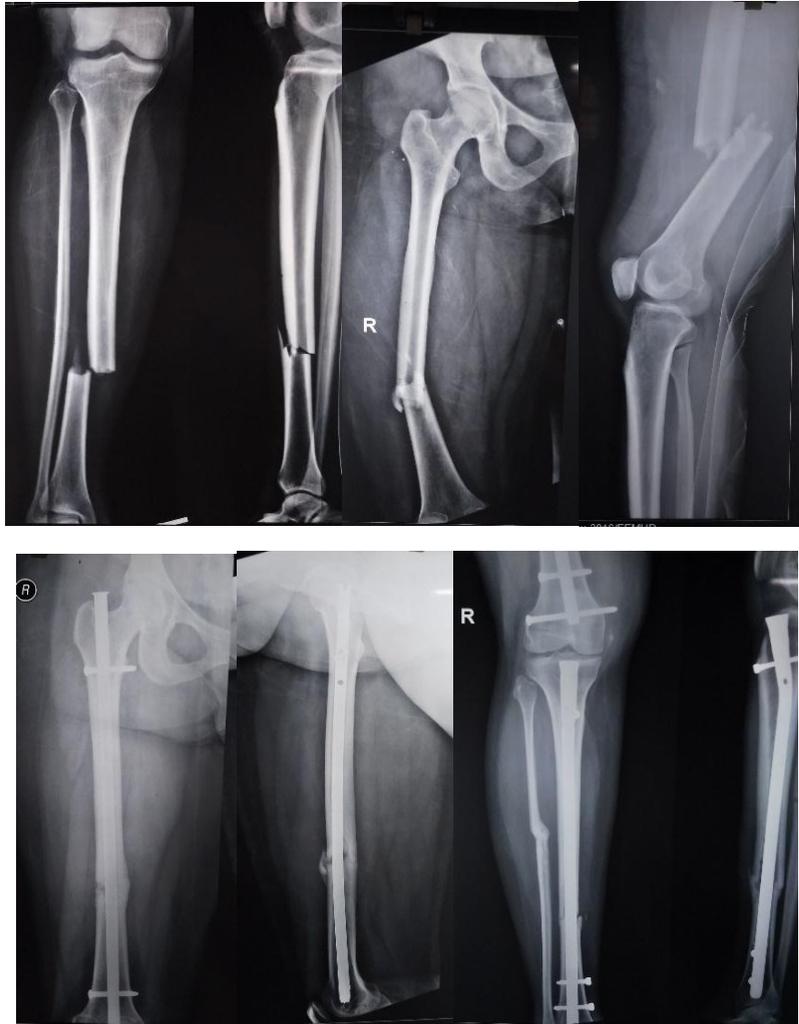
McBryde and Blake type I fracture pre op and 9 months post op follow up x-rays
